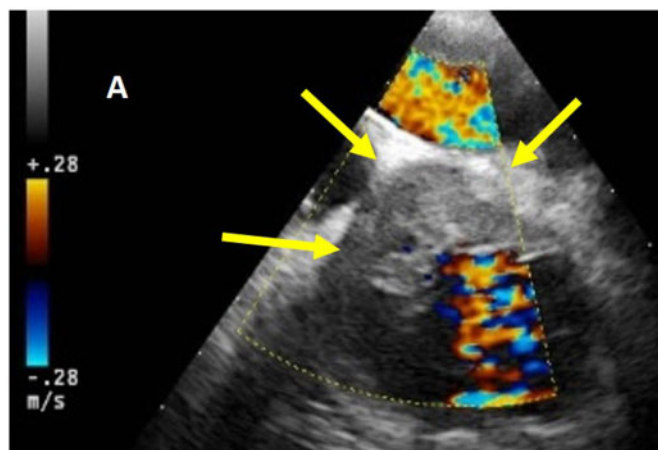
Transoesophageal echocardiography showing an echo lucent space with thickening at the aortic root consistent with an abscess extending around the aortic prosthesis (A, short axis), reaching the first part of the ascending aorta (B, 129°).
